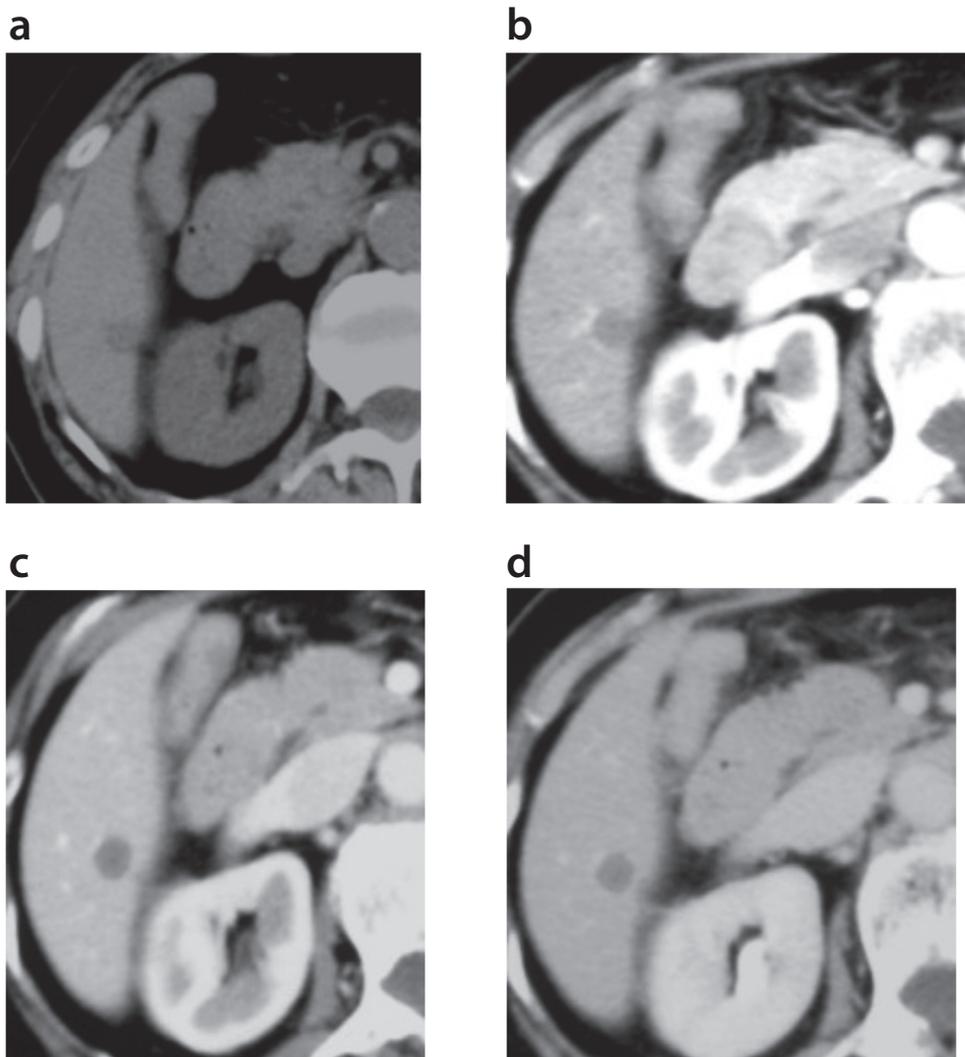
Abdominal Computed Tomographic Findings
